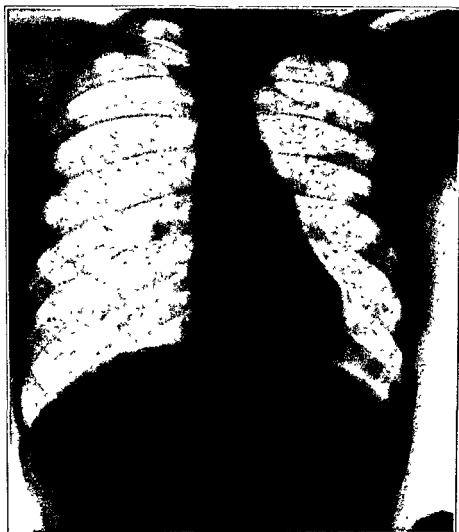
An x-ray demonstrating a check-valve cavity in the left upper lobe. Subsequent Figs 52 and 53 demonstrate the spontaneous closure and reopening of the cavity.
